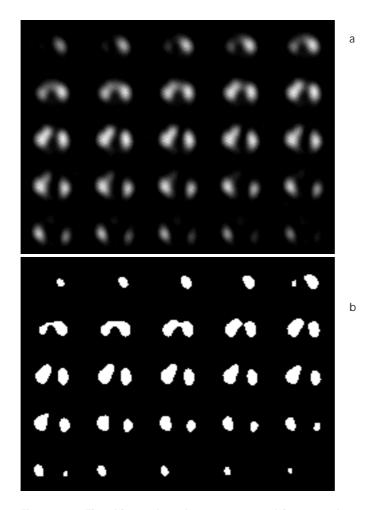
Thyroid SPECT in patient #6; a: transaxial cross-sections, and b: the same cross-sections segmented with a 45% threshold.
